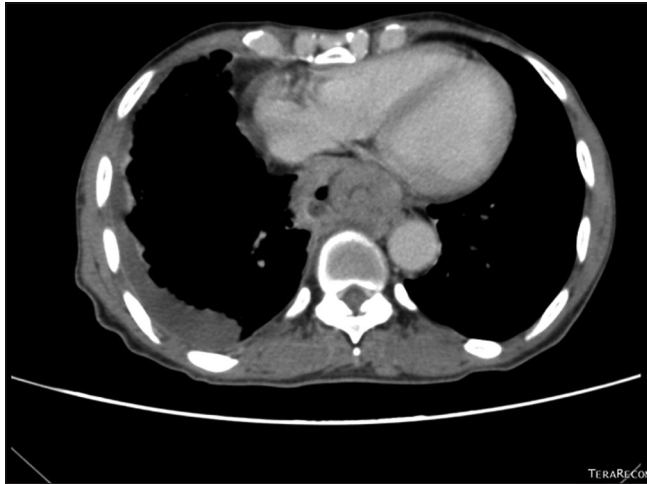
Axial section of contrast-enhanced computed tomography chest shows lumen within lumen appearance of thoracic esophagus suggestive of intussusception
